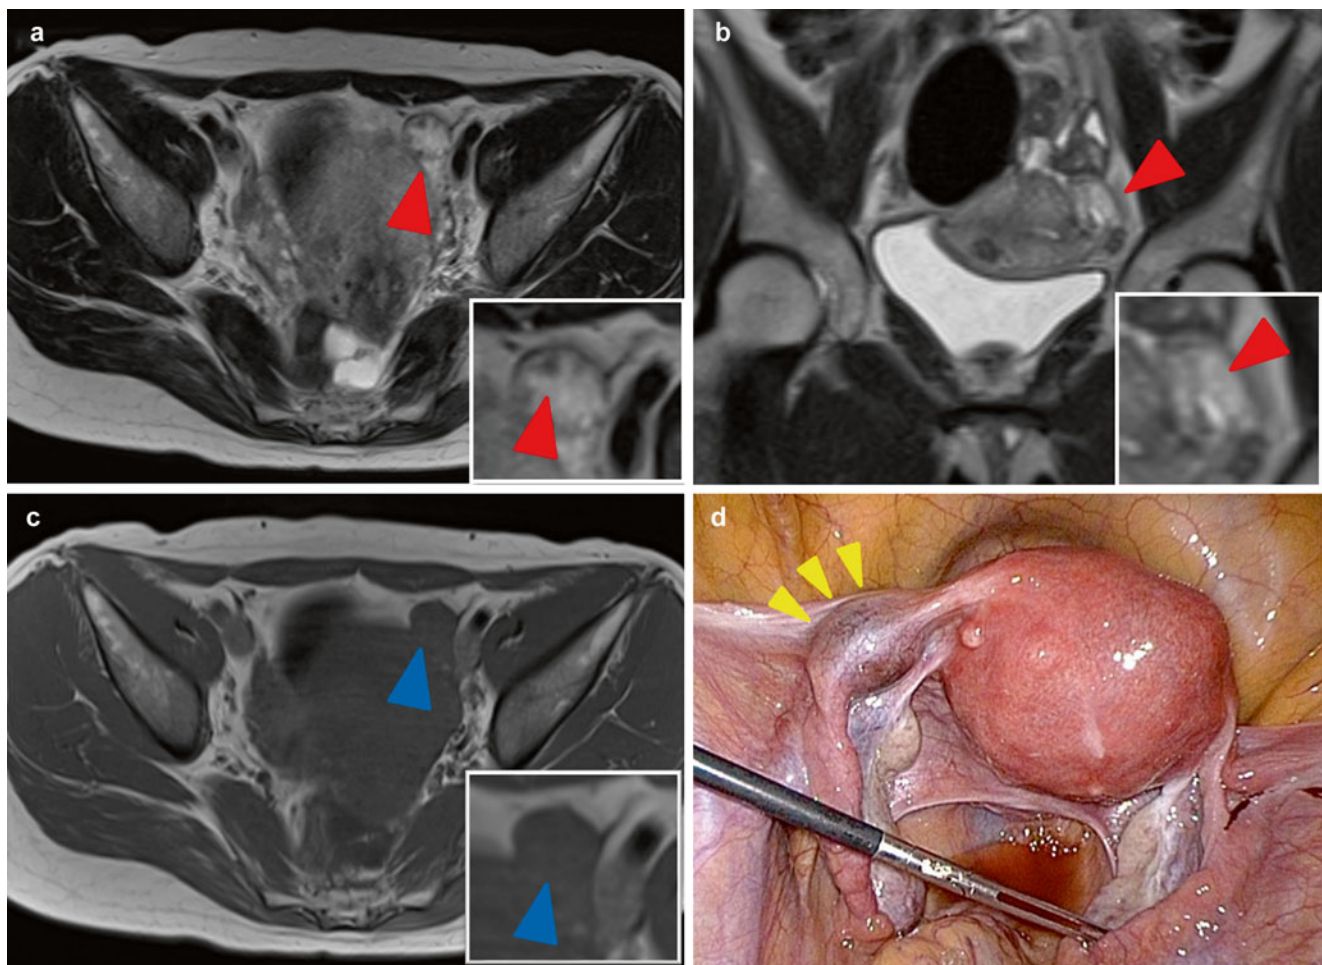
Magnetic resonance imaging (MRI) of left tubal isthmus pregnancy at 5 weeks of gestation. A cystic gestational sac-like mass on the left side of the uterus shown on axial (a) and coronal (b) T2-weighted images as high-intensity areas (red arrowheads). The
